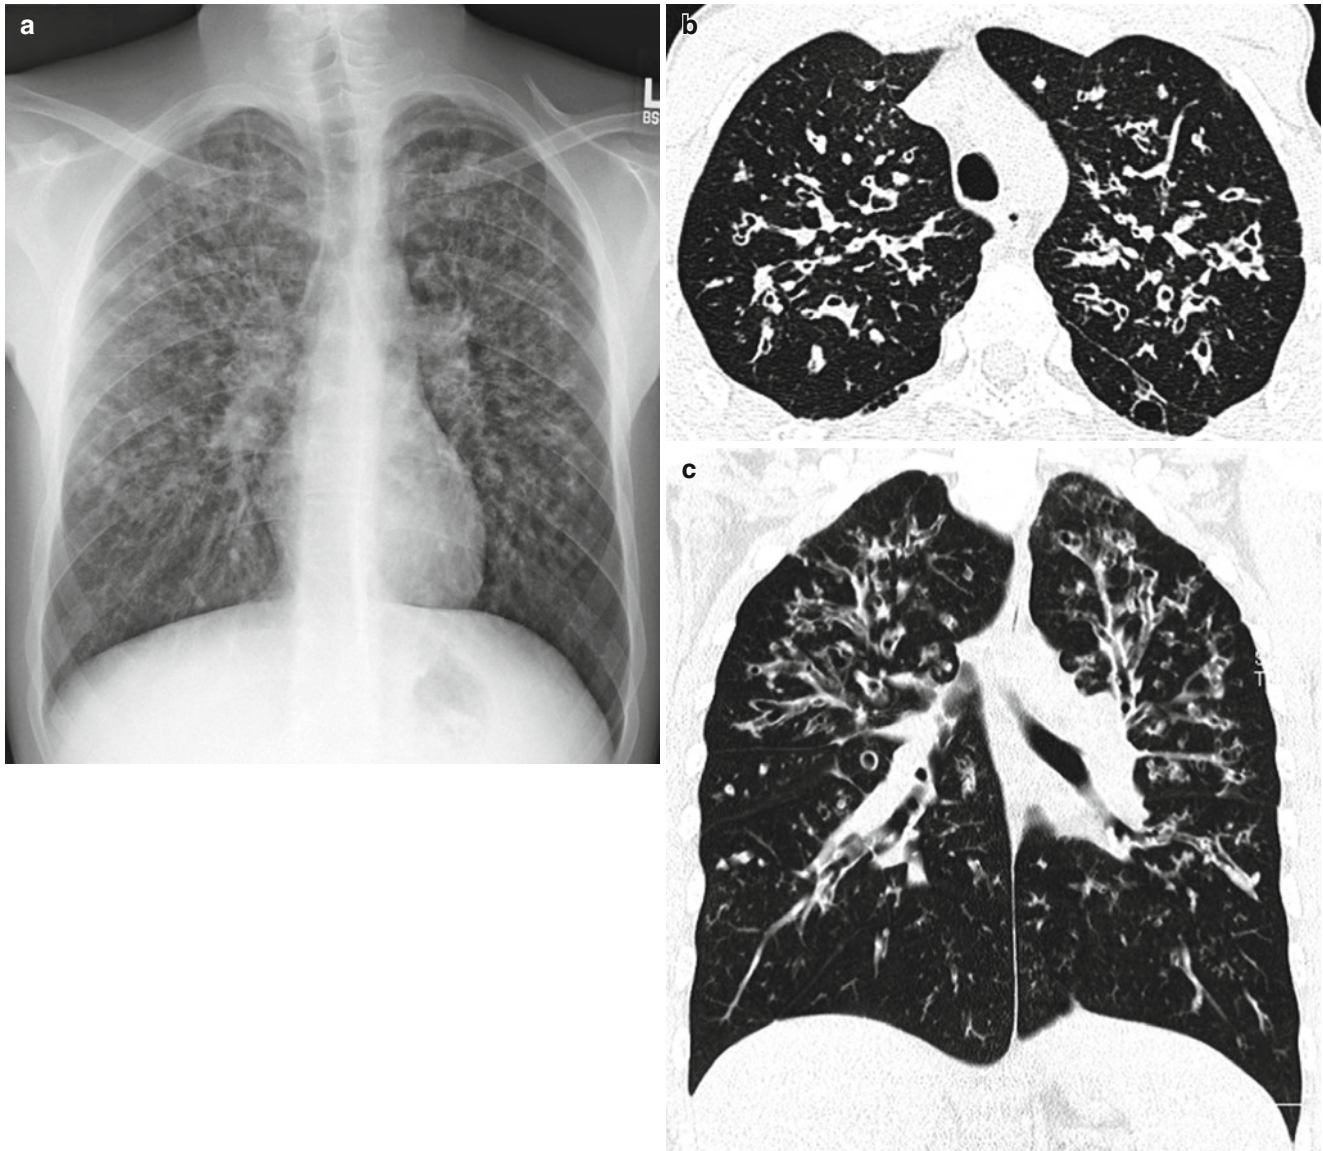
Cystic fibrosis in a 15-year-old girl. (a) Frontal chest radiographs demonstrates diffuse bronchiectatic lung changes and areas of nodular opacities likely related to underlying mucus plugging. (b)
